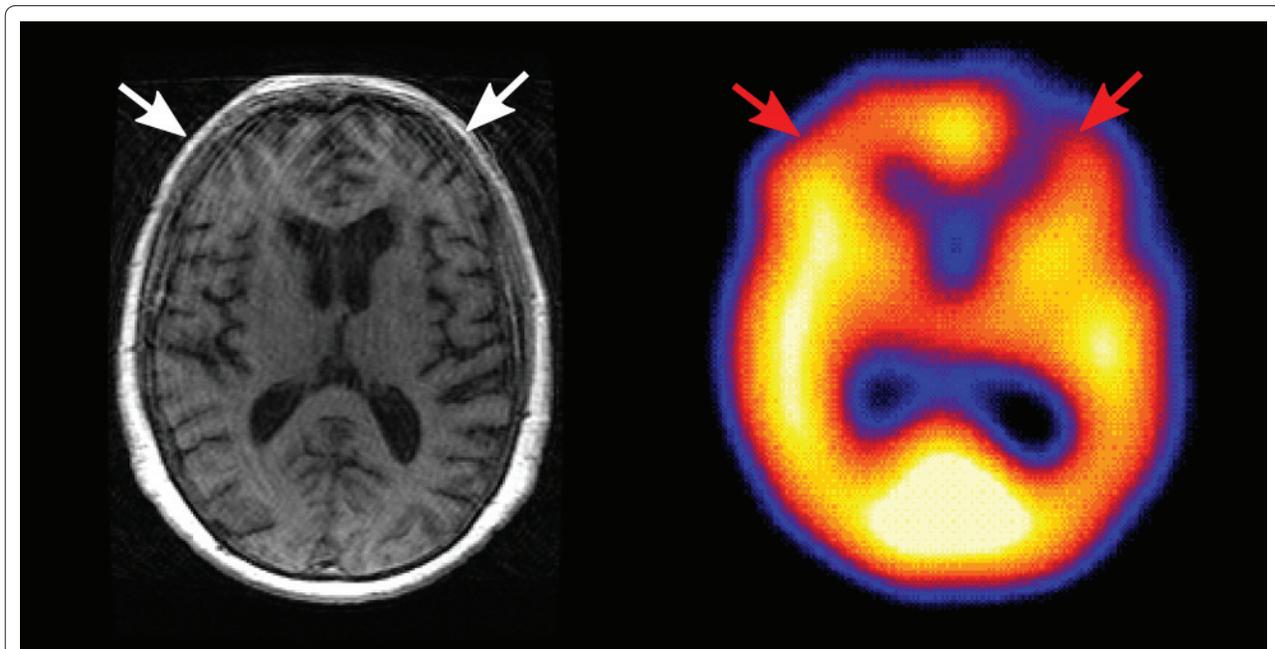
Right/visuoperceptive variant Alzheimer's disease. A 64 year old man presenting with short-term memory loss and difficulty with visually guided tasks (reading clocks and music). Imaging done 3 years into the course of illness, including axial T1 MRI at the level of the midbrain (top left), demonstrated subtle right, greater than left, temporal and parietal atrophy with relative expansion of right lateral ventricle and increased right parietal sulcal markings (white arrows), less evident at the level of the basal ganglia (bottom left). At the same time, axial single-photon emission computed tomography (SPECT; right) demonstrated right hypoperfusion, particularly in the parietal region (red arrows). The patient died 5 years into the course of disease, and autopsy confirmed Alzheimer's disease (Braak V/VI).
